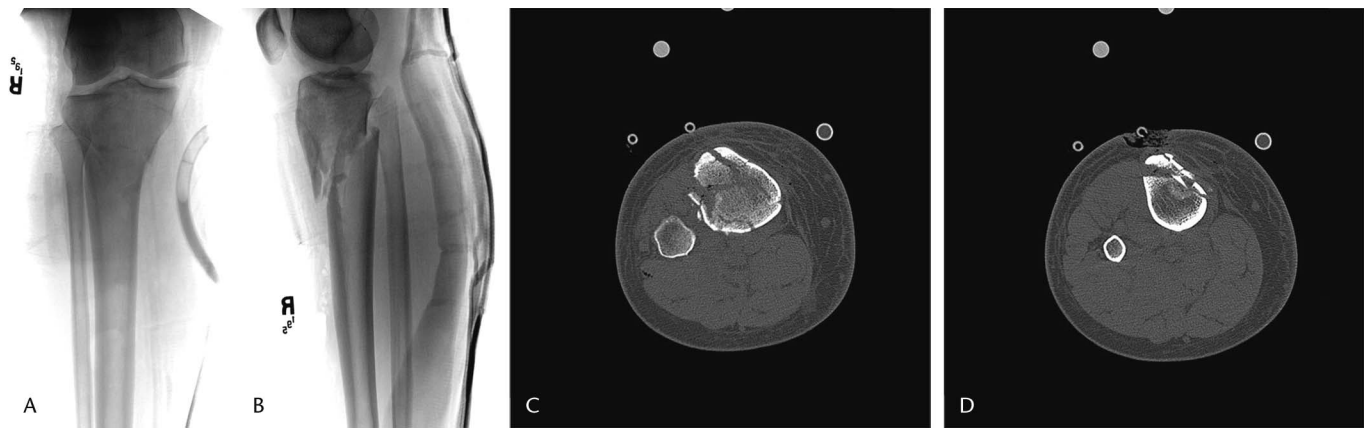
A–D, Anteroposterior and lateral radiographs demonstrating a C-type tibial plateau fracture. Representative axial computed tomography images demonstrate the tibial tubercle fragment.
